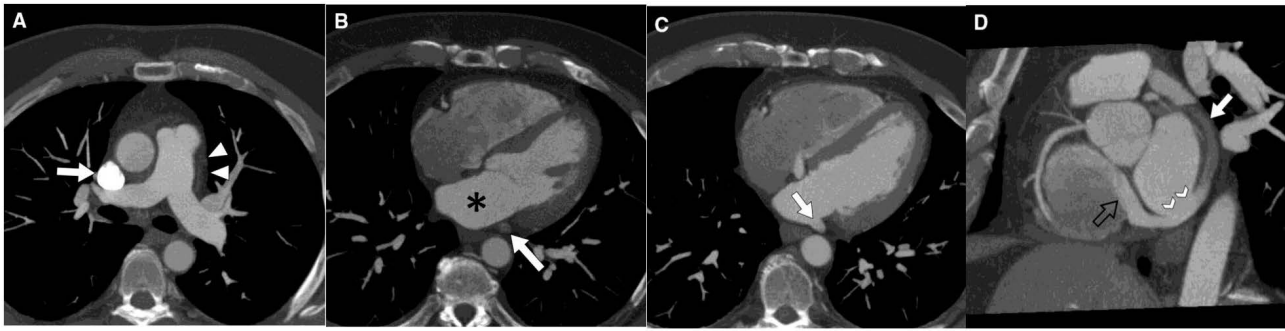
Contrast-enhanced cardiac CT images revealing unroofed coronary sinus (CS). (A) Axial MIP image at PA level demonstrates a right SVC (arrow) with absence of left SVC (arrowheads). (B) Axial MIP image at midventricular level shows CS (arrow) unopacified and separated by fat plane from LA (*). (C) Axial MIP image 2 cm inferior to (B) shows CS unroofed (arrow) and with same opacification as LA. (D) Multiplanar reformatted image in valve plane shows CS partially unopacified (arrow), site of unroofing (arrowheads), and jet of dense contrast entering the right atrium through the coronary sinus valve due to the left-to-right shunt (black open arrow). Figure adapted and reprinted, with permission [100].
